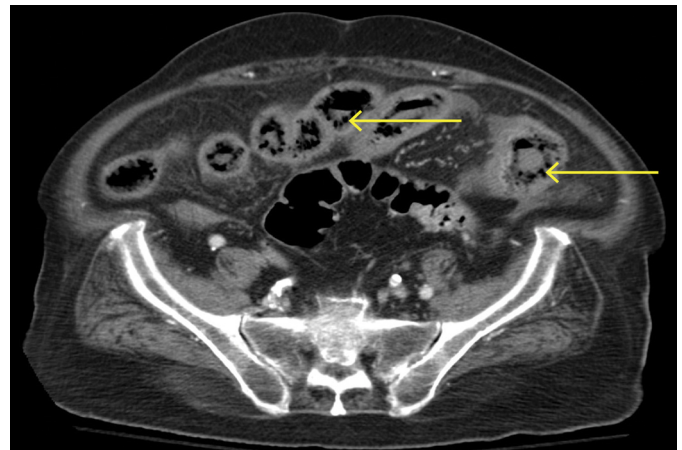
Abdominal CT showing air within the wall of the small intestine (arrow).
